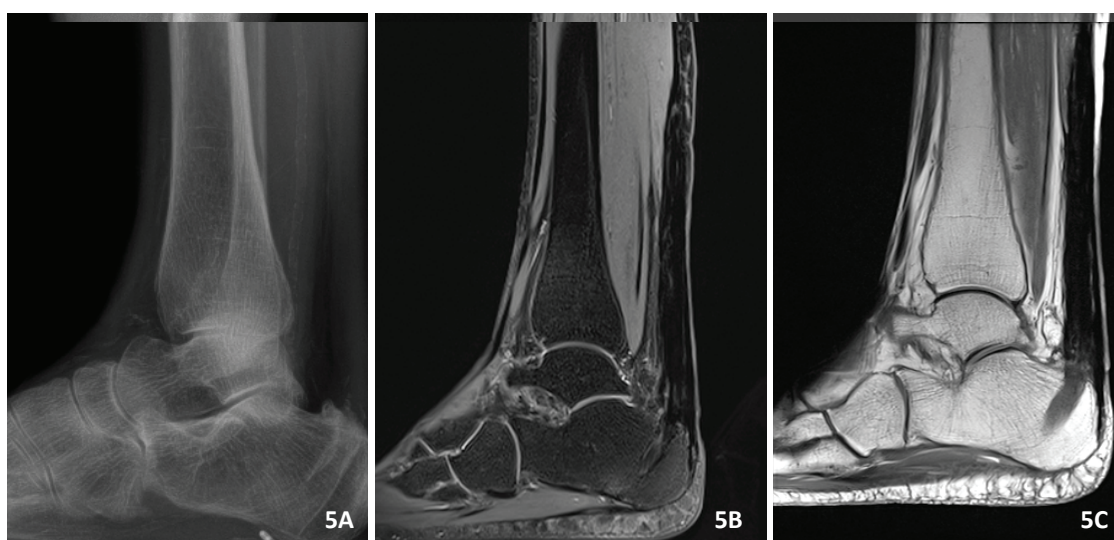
3-year postoperatively X-ray image of the right Achilles tendon; 5B and 5C - MRI scans of the reconstructed right Achilles tendon.
